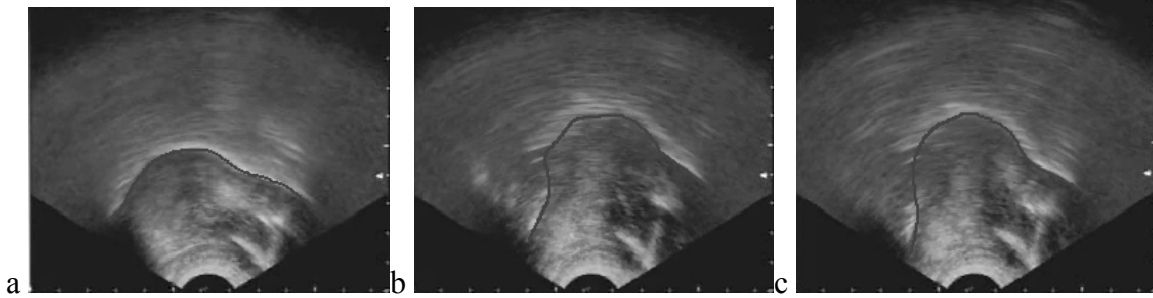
Midsagittal ultrasound view of the tongue showing tracing of the tongue surface during /a/, /i/, /u/ vowel production. The anterior tongue points to the right side of the images. a) Ultrasound image during /a/. b) Ultrasound image during /i/. c) Ultrasound image during /u/.
